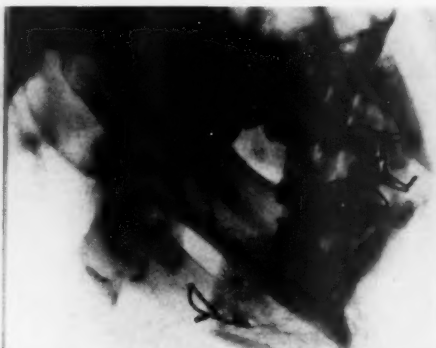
(Case 2.) Roentgenogram showing bone graft from crest of ilium to restore continuity of mandible (Dr. Carl Kornblum).
